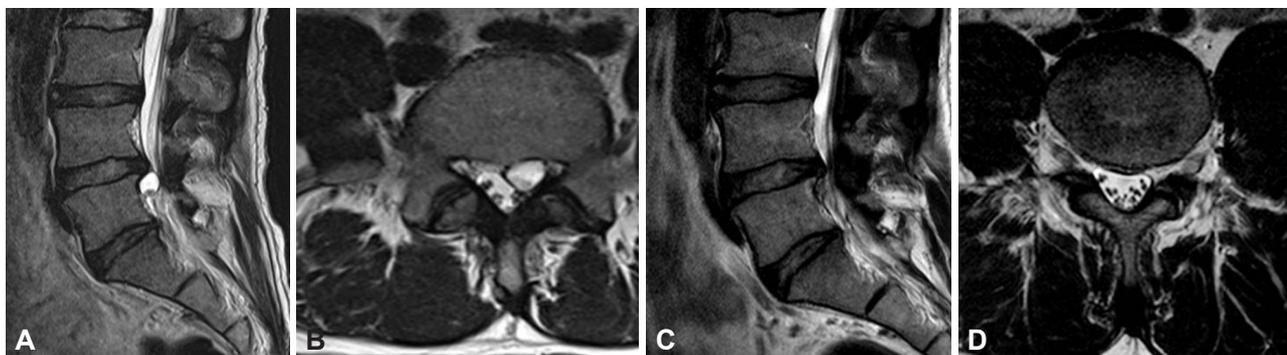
Preoperative MRI. A : T2-weighted sagittal image of discal cyst on Lumbar L4–5. B : T2-weighted axial image of discal cyst. C : Post-operative T2-weighted sagittal image. D : T2-weighted axial image demonstrating the complete disappearance of the discal cyst.
